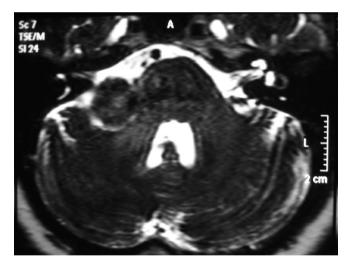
Axial T2-weighted MRI of the posterior fossa showing no involvement of the right internal auditory meatus.
